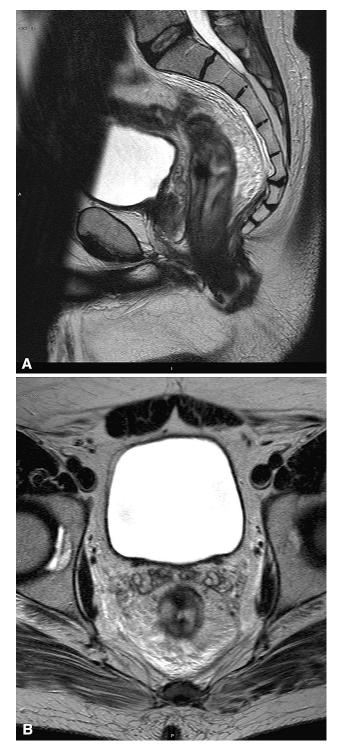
Acute radiation change to rectum. Sagittal T2W (A) and axial T2W (B) MR images, show thickened edematous rectal wall with high signal to the submucosa and low signal to the outer wall consistent with acute radiation change to the rectum. This occurred after long course pre-operative radio-therapy for upper rectal cancer, in a patient who received 45 Gy in 25 fractions over 5 weeks.
